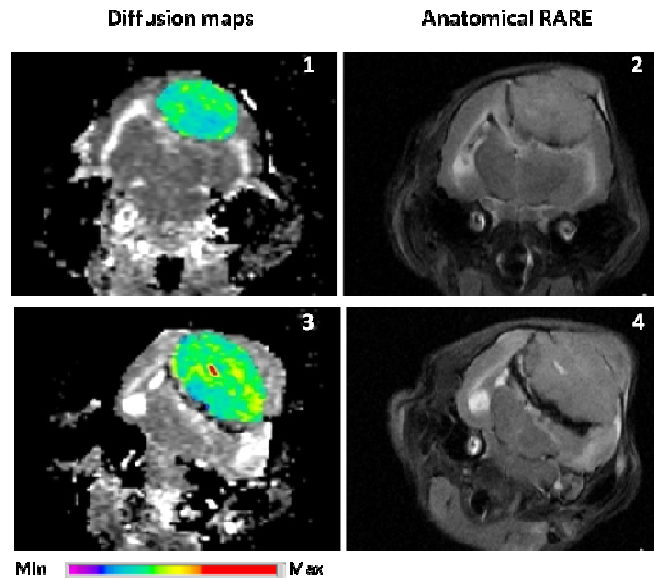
Color-coded MRI diffusion maps (1,3) with corresponding anatomical RARE images (2,4) at 20 (1,2) and 30 days (3,4): tumors are encircled by white dotted lines on RARE images. Higher diffusion coefficient values are depicted as yellow or red areas.
